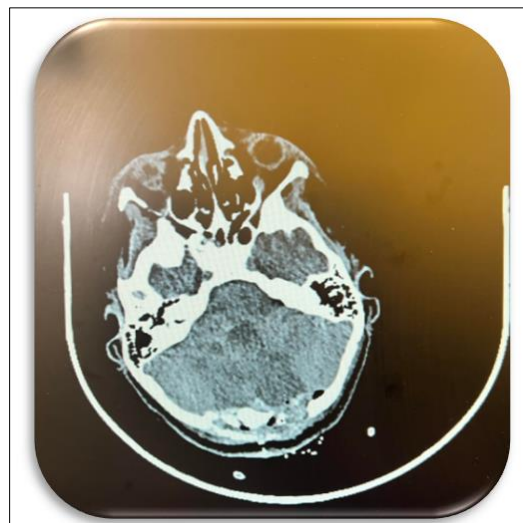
Non-contrast brain CT scan showing Postoperative minimal oedema
